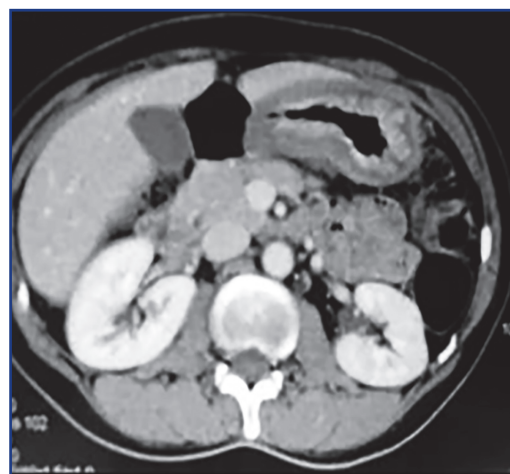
Computed tomography of the stomach in diffuse gastric cancer [1]
